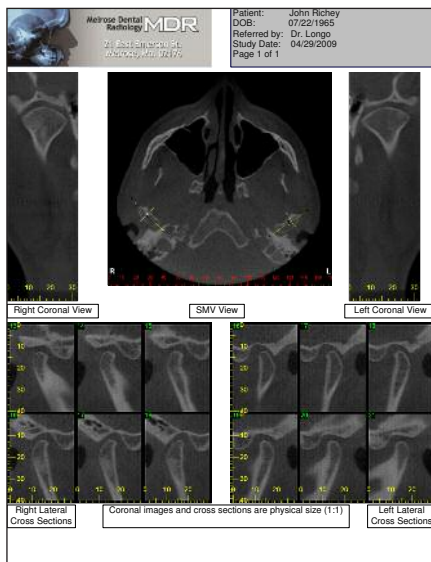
Three-dimensional cone beam scan was taken without the maxillary anterior-guided orthosis (MAGO) (bite splint) in place.
